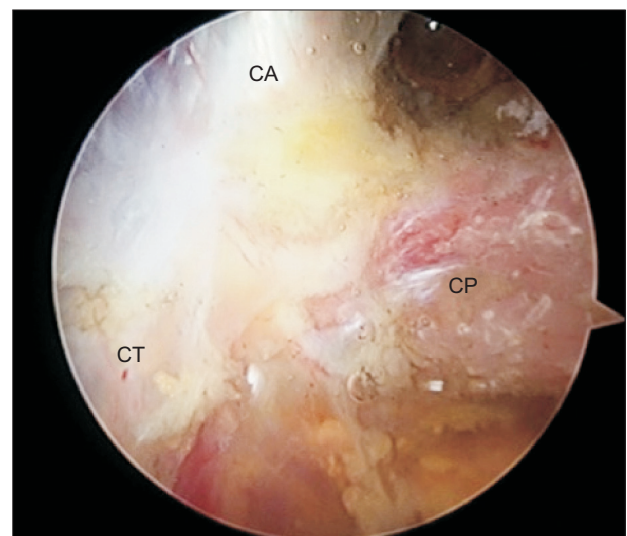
The coracoid process (CP), the coracoacromial (CA) ligament, and the conjoint tendon (CT) are visualized.
